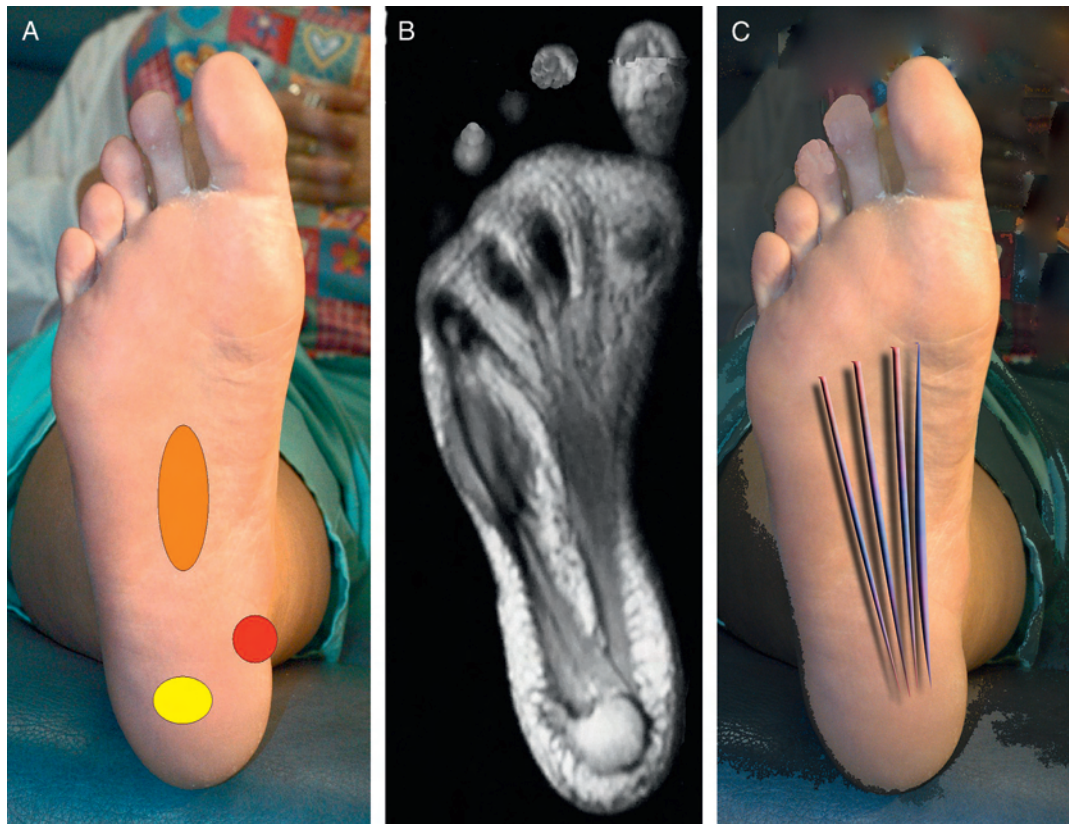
(A) With plantar fasciitis, tenderness may be localized centrally along the plantar fascia (orange oval), along the plantar medial tuberosity (red circle), or directly plantar to the calcaneal tuberosity (yellow oval). (B) The anatomy of the plantar fascia as shown through MRI. (C) Depicted here are the lines of tension of the plantar fascia and its majority insertional attachment to the medial calcaneal tuberosity.
